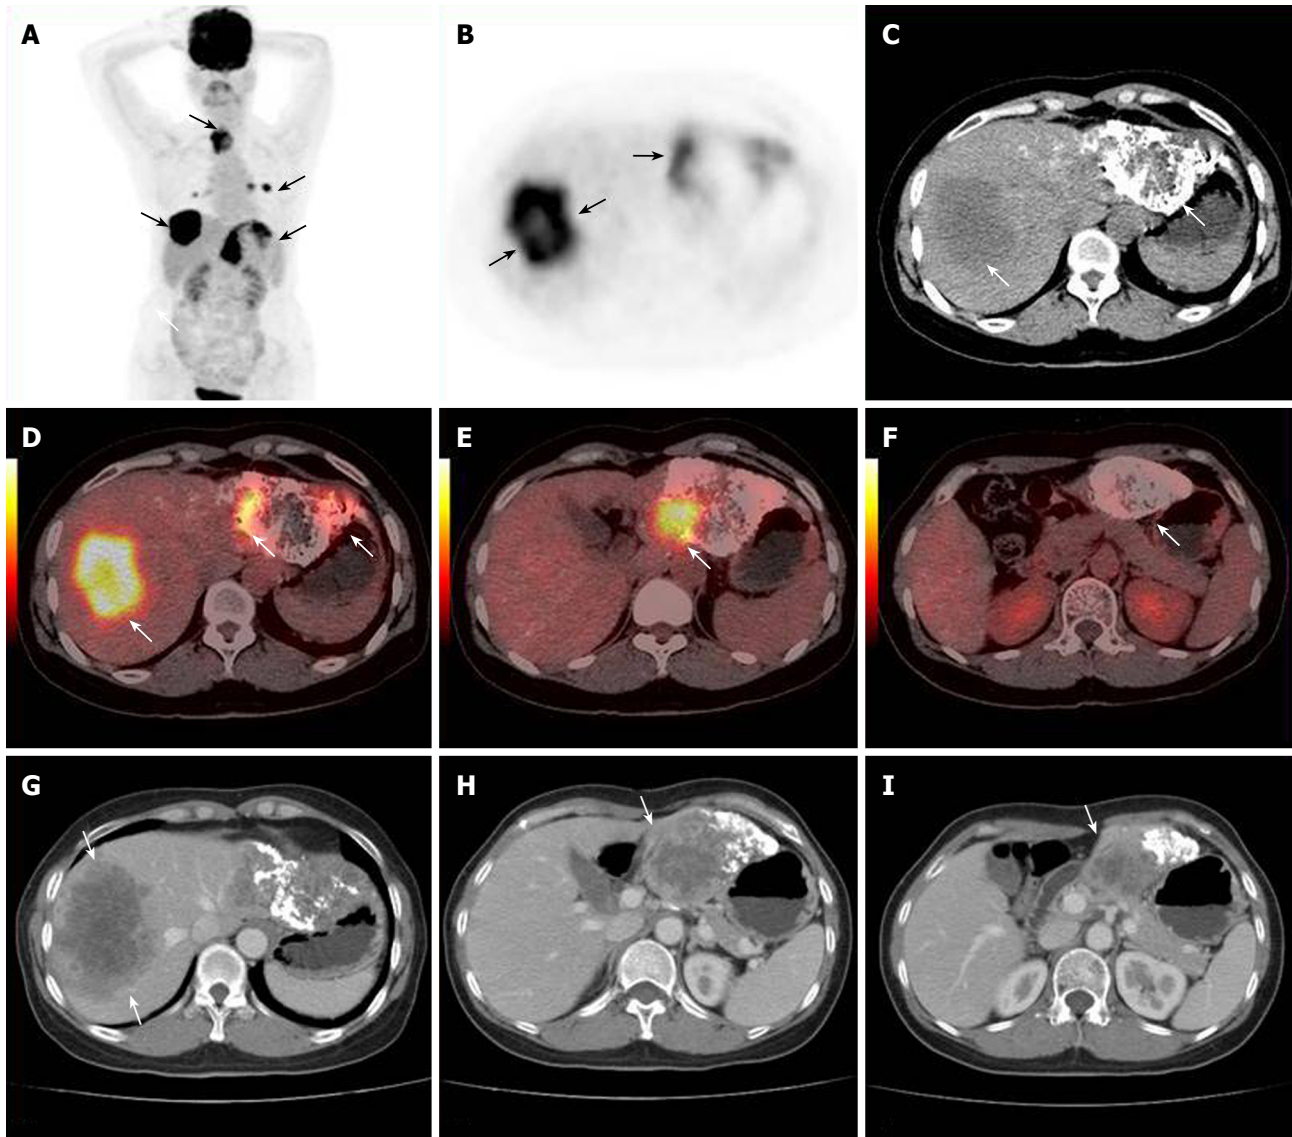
A 55-year woman suffering from HCC received TACE treatment. Extrahepatic metastases (arrows, A) were detected by PET and PET/CT fused images. Highly metabolic new recurrent lesion of the right lobe (arrows, B-D) and a resident lesion of the left lobe (arrows, E, F) were detected by PET/CT fused imaging. Contrast-enhanced CT follow-up after 1 mo later confirmed the progression of lesions.
